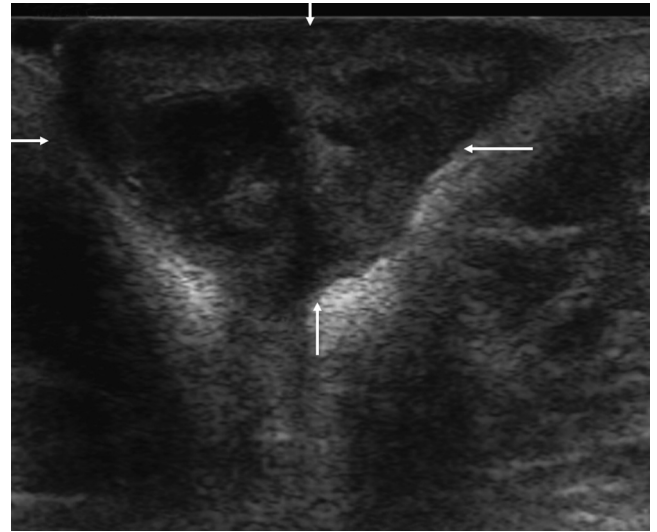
Abdominal wall abscess. Transverse sonogram of the umbilicus in a middle-aged patient with fever and increased white blood cell count. There is a mixed hypo- and anechoic mass (arrows) in the umbilicus, with low-level echoes, consistent with abscess formation in the umbilicus.
